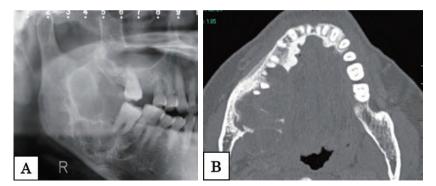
Panoramic radiograph of an A-S/M patient (same case shown in Fig.5-1-1). (A) Multilocular radiolucent region with a sharp margin located in the ramus of the mandible. (B) CT shows multicystic lesion extending to the lingual side of the mandible.
